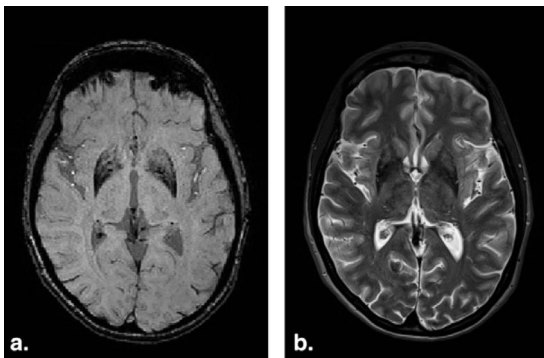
Difference between susceptibility-weighted imaging (SWI) and sampling perfection with application-optimized contrasts using different flip-angle evolutions (SPACE) sequences. Example slices from (a) three-dimensional SWI and (b) T2-weighted three-dimensional SPACE series.
